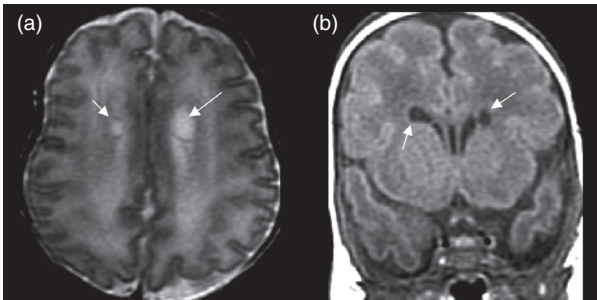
Cystic PVL: (a) axial T2 and (b) coronal FLAIR MRI, chronic cystic phase (arrows).
